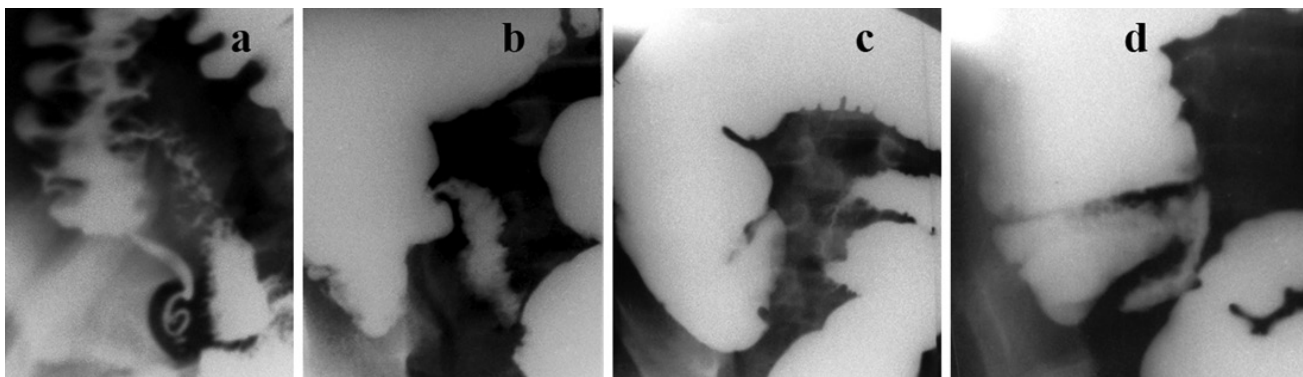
X-ray signs of acute appendicitis, (a). The AX is uniformly and deeply filled with barium. Acute appendicitis is excluded, (b). Concavity of the inner part of the dome of the cecum in the patient with acute appendicitis. The ileum and sigma are removed from the cecum. This is a symptom of the “window”. An omentum occupies the distance between cecum and sigma, (c). The inner contour of the cecum is slightly concave and uneven. Spasm of sigma located opposite the cecum, (d). There is a concavity of the inner contour of the cecum in combination with a sharp shortening of the dome. The spasm of the terminal ileum and symptom of the “window” make the diagnosis of AA obvious.
